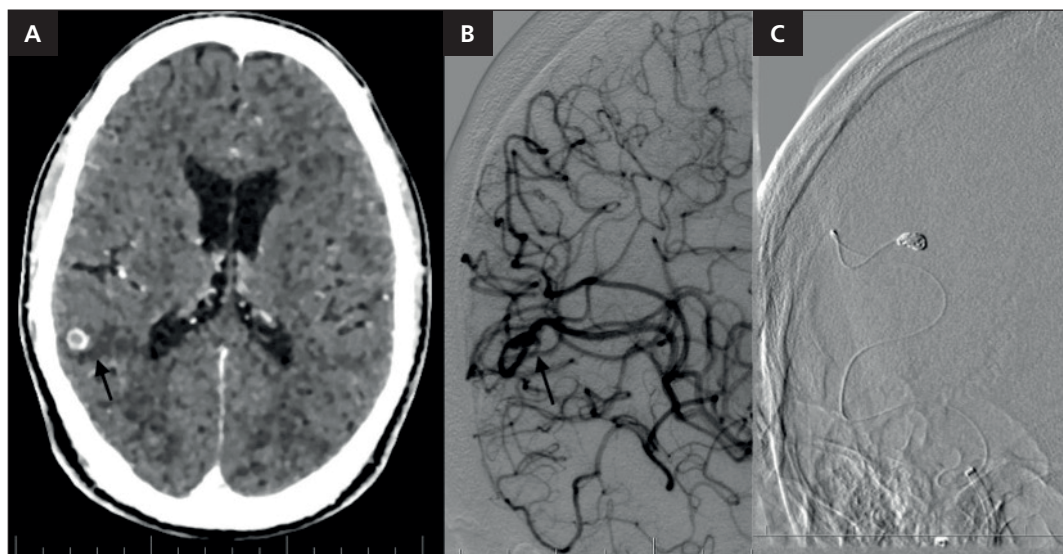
Brain imaging. (A) Head computed tomography shows fusiform aneurysm of the right medial cerebral artery and intracerebral hemorrhage in parietooccipital lobe (arrow) on axial view. (B) Digital subtraction angiography (DSA) shows aneurysm (arrow) of the right medial cerebral artery. (C) Seven coils were inserted into the aneurysm.
